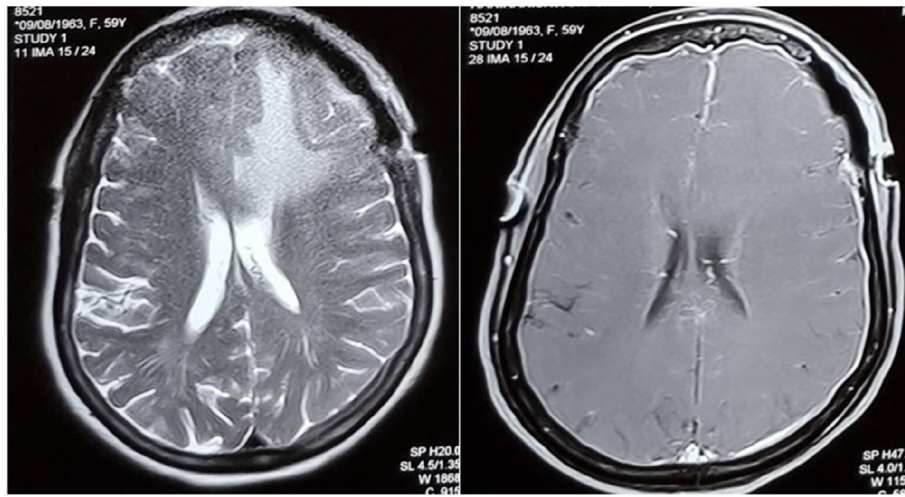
jpg: Axial T2 (left) and post contrast (right) MRI brain showing complete excision of tumour.
